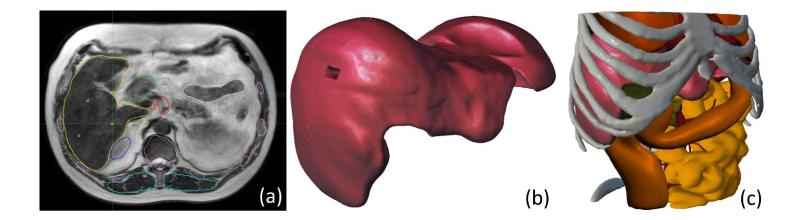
(a) Representative example of patient T2-weighted MRI used in planning the placement of a dosimeter in the liver. (b) Model of liver showing the planned position of dosimeter holder. (c) Assembled STL model prepared for 3D printing.
